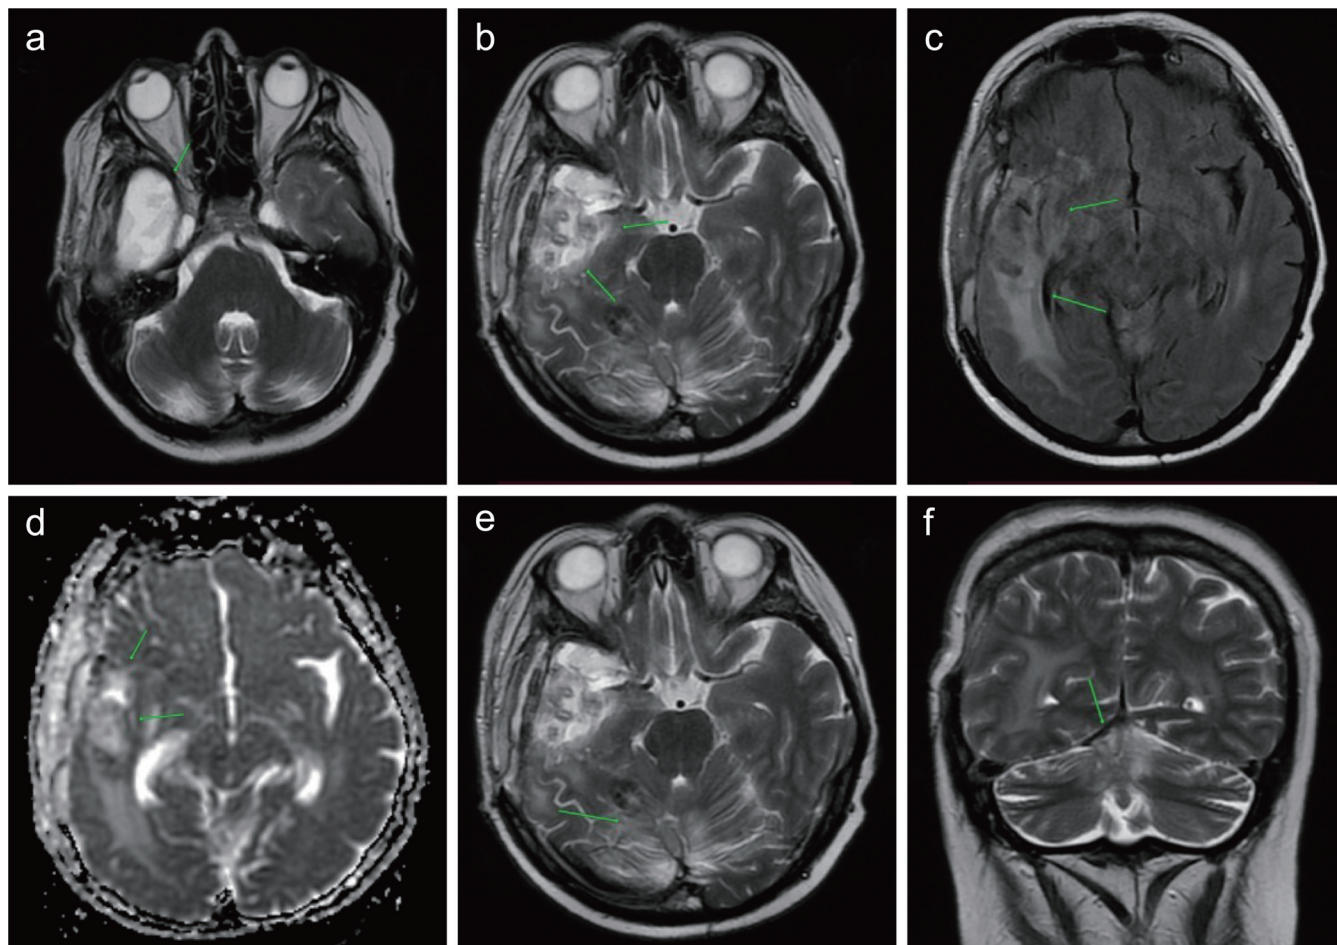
Postoperative state after tumor resection in the right temporal lobe (March 5, 2022). In the right temporal lobe, a pathological zone with unclear margins is identified, including a cyst (a), residual tumor (b), and a gliosis-affected area visible on T2-weighted image (T2WI) and fluid attenuated inversion recovery (FLAIR) sequences with surrounding perifocal edema (c) and signs of restricted diffusion on diffusion-weighted imaging (DWI) (d). In the region of the cerebellar vermis and right cerebellar hemisphere, a zone of cystic-gliotic changes is identified (e, f). Displacement of midline structures is also observed (f).
